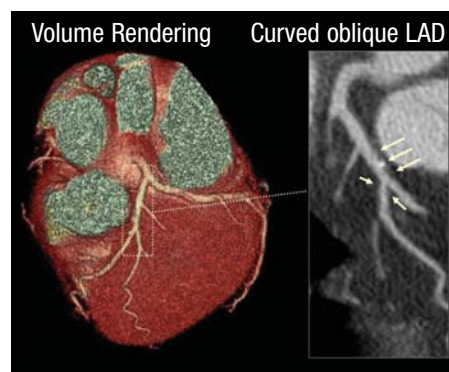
CT coronary angiography volume-rendered 3D view of left anterior descending artery (LAD) circulation (left), along with curved oblique view (right), shows vascular remodeling and mixed plaque with small amounts of calcification in LAD, close to branching of first diagonal (arrows). Plaque was judged to be nonobstructive.
